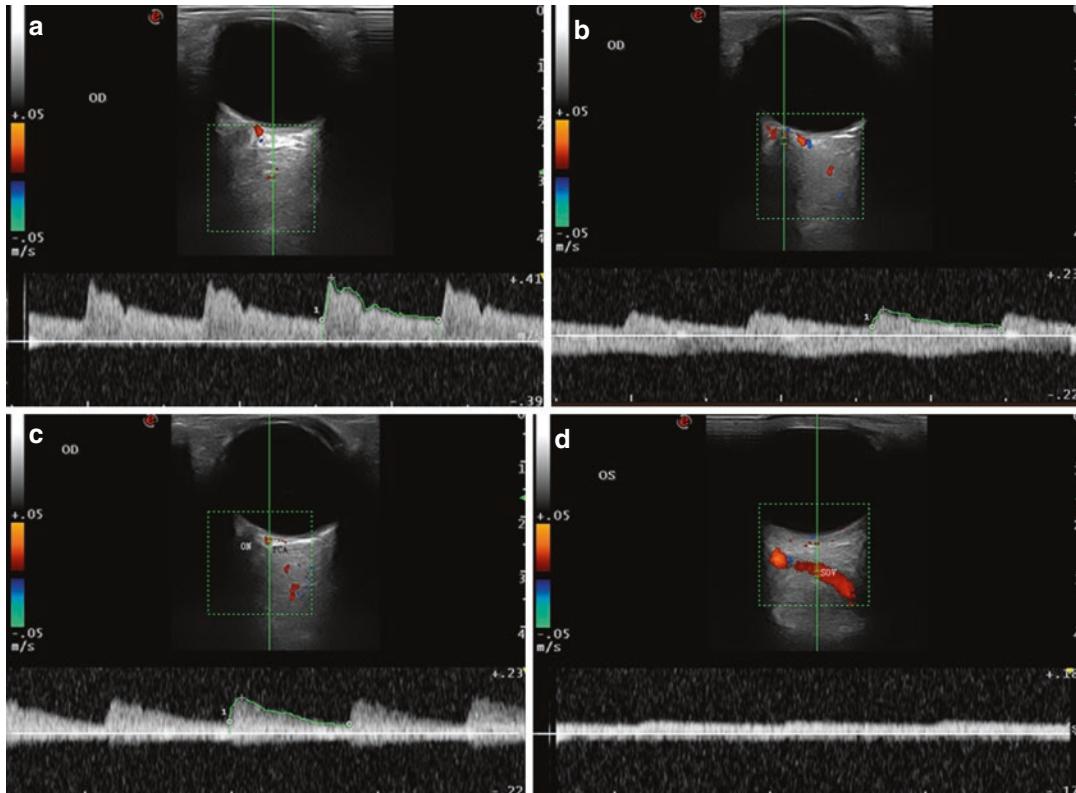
Color Doppler and pulse Doppler imaging of the eye. Note: (a) OA ophthalmic artery, (b) CRA central retinal artery, (c) PCAs posterior ciliary artery short, (d) Superior Ophthalmic Vein
